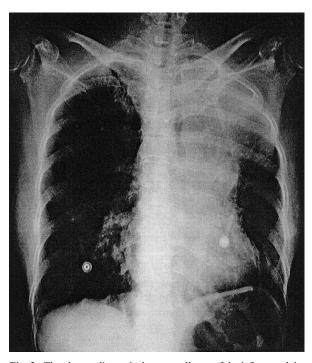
The chest radiograph shows a collapse of the left upper lobe on the 3rd day of admission, when patient's condition deteriorated again into respiratory failure.
